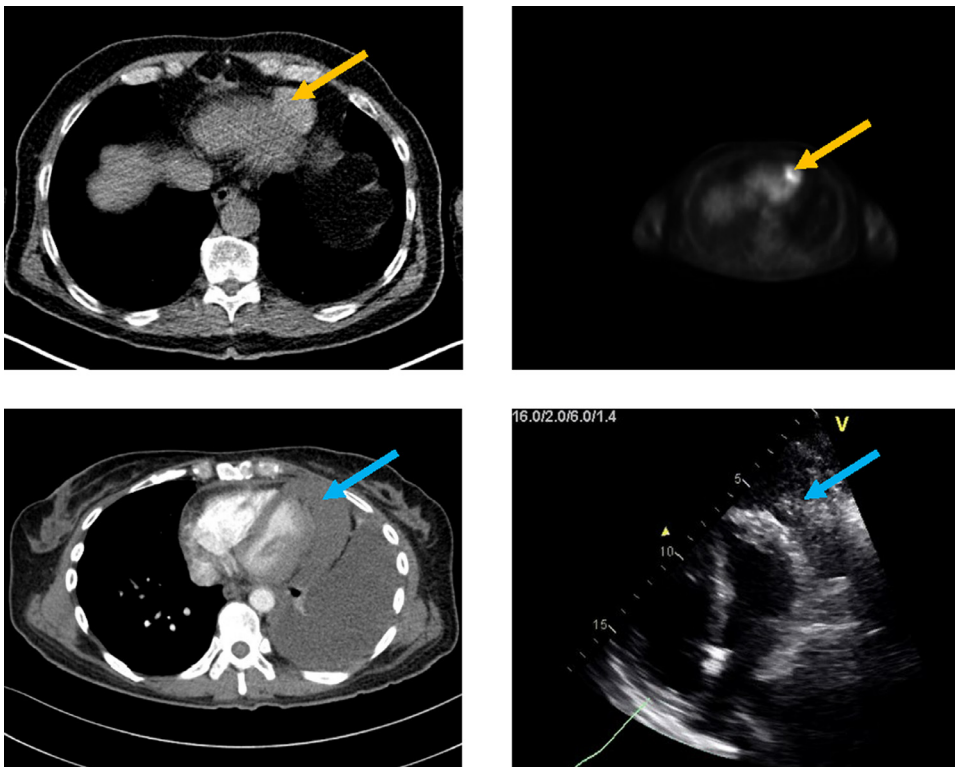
Positron emission tomography - computed tomography (PET/CT) (1A) showing a pericardial mass with increased uptake (orange arrow). In another patient (1B), computed tomography and echocardiography four-chamber view depicting a large pericardial mass (blue arrow).
